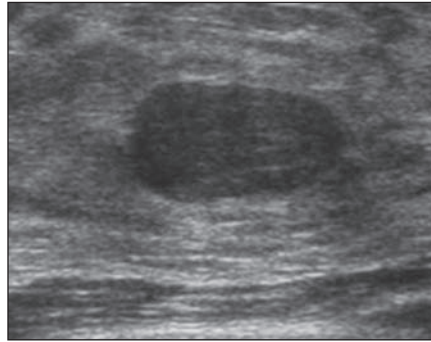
14-year-old girl with palpable breast mass. Sonogram shows well-circumscribed 3.3-cm ellipsoid hypoechoic mass with increased through-transmission and pseudocapsule. Excisional biopsy revealed fibroadenoma.
